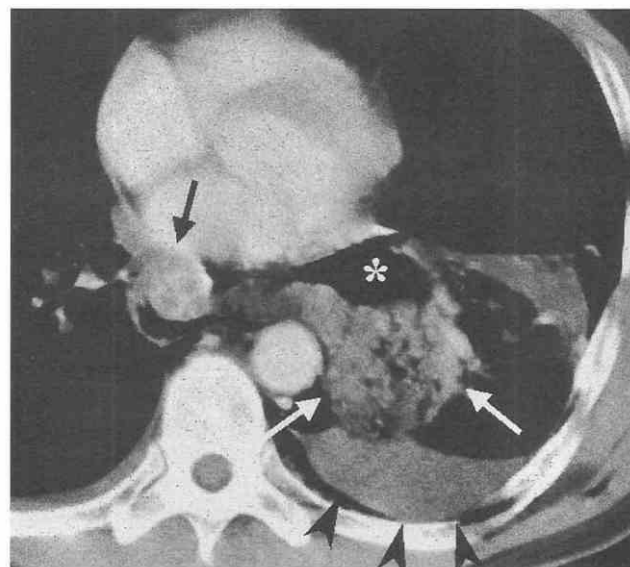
Esophageal perforation (Boerhaave's syndrome) in a 56-year-old man. After vigorous vomiting, the patient experienced sudden chest pain. CT scan shows a thickened esophageal wall (arrow), pneumomediastinum (asterisk), regurgitated gastric content (white arrows), and pleural effusion (arrowheads).
